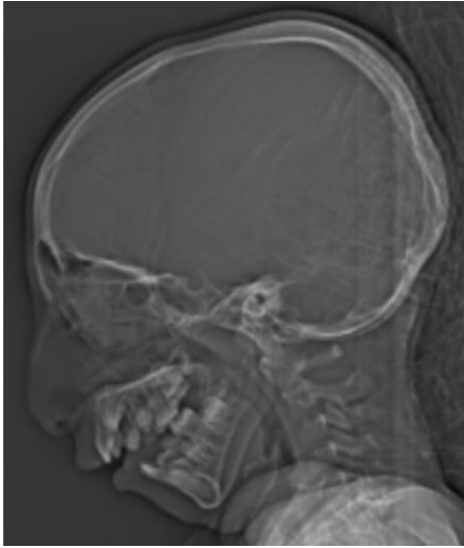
Computed tomography (CT) scanogram showing retrognathia, hypoplastic mandible (micrognathia), and an obtuse mandibular angle.
